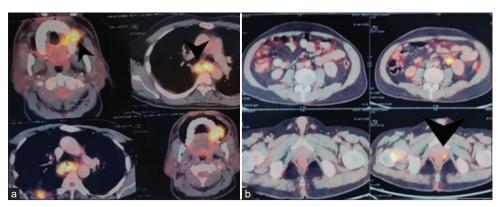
Whole body PET-CT scan showing (a) fluorodeoxyglucose (FDG) active lesion in esophagus, 5th rib and left upper alveolus; (b) high FDG uptake lesion in posterolateral wall of prostate with skeletal lesion (Case 1)
